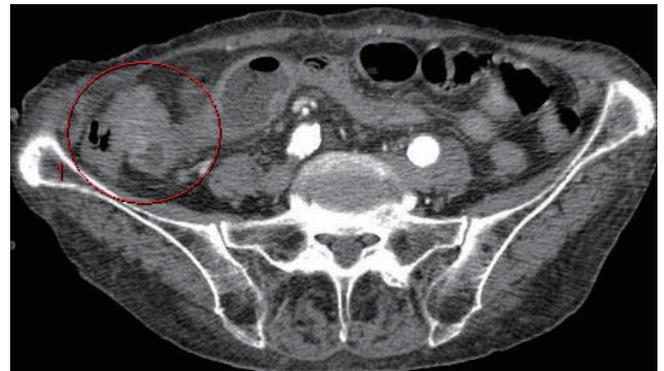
Contrast-enhanced CT scan of abdomen showed 31 x 23 mm lesion in right iliac fossa with distal ileal and cecal involvement (within red circle).
